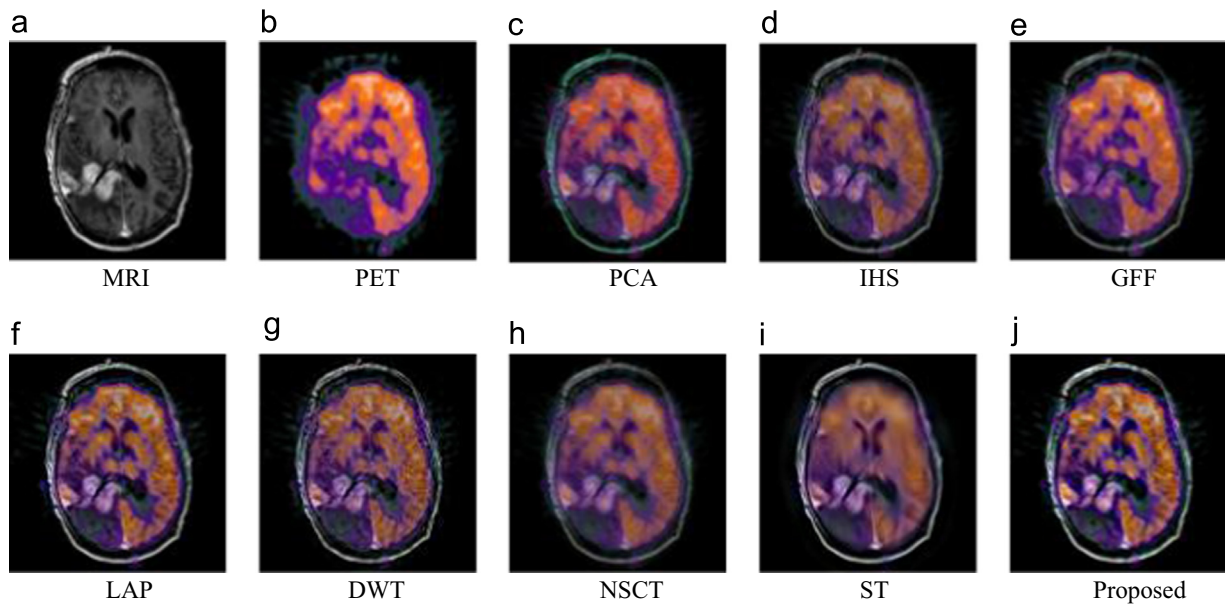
Example 1: Performance comparison of different methods on MRI-PET fusion.
